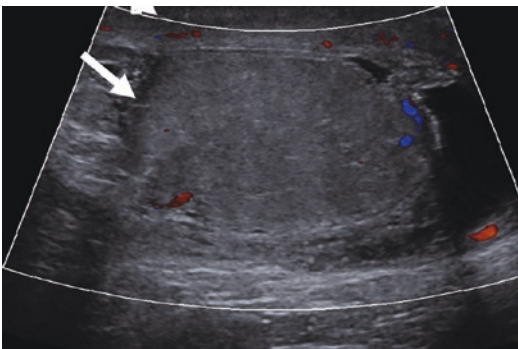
Doppler US showing an edematous testicle (white arrow) 4 days after inguinal hernia repair. Since no arterial flow was established, a trans-scrotal orchiectomy was indicated
